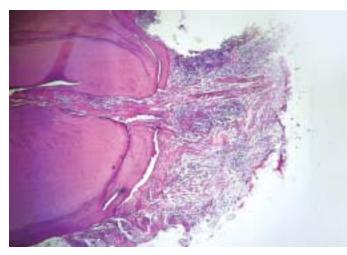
Periapical granuloma—Granulation tissue showing proliferation of both fibroblasts and endothelial cells. Small vascular channels are also seen
